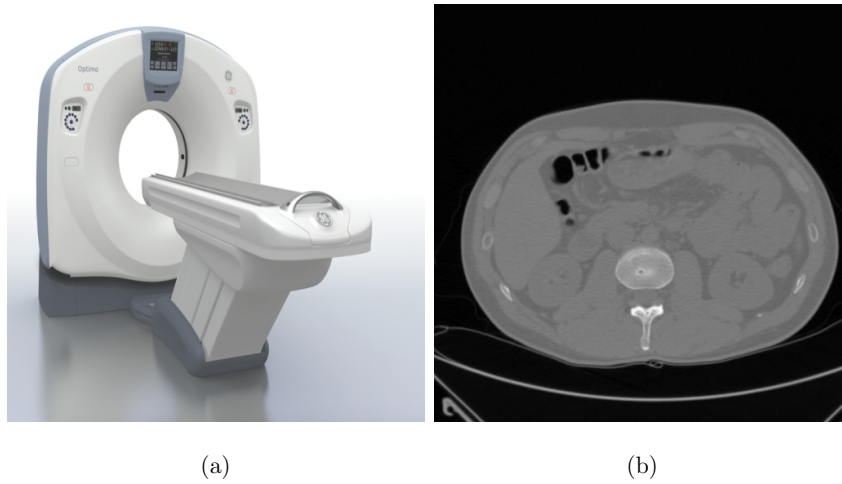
The figure (a) shows a CT machine [2] and the figure (b) is an abdominal CT image.
